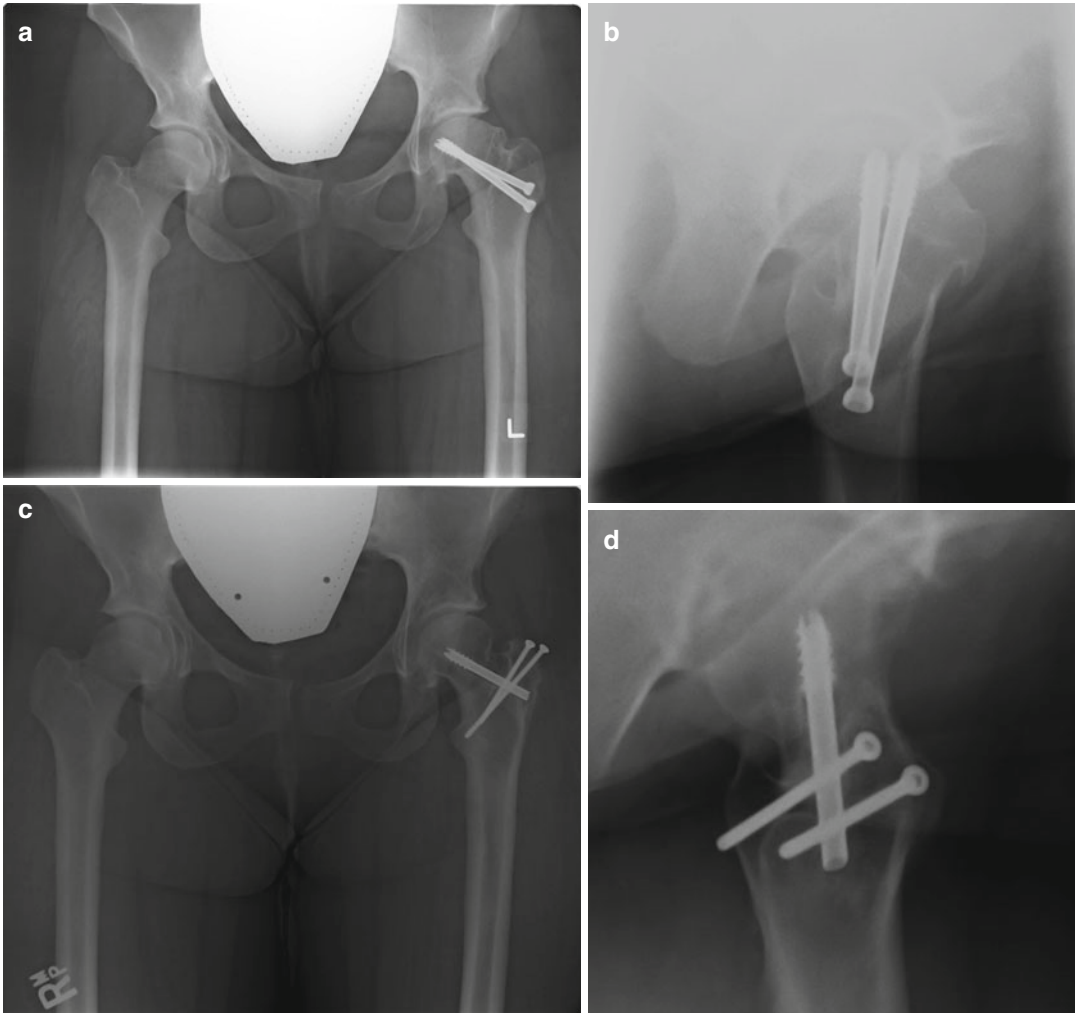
Radiographic (a) anteroposterior and (b) lateral views of a 22-year-old female with a healed slipped capital femoral epiphysis and clinical symptoms and signs
